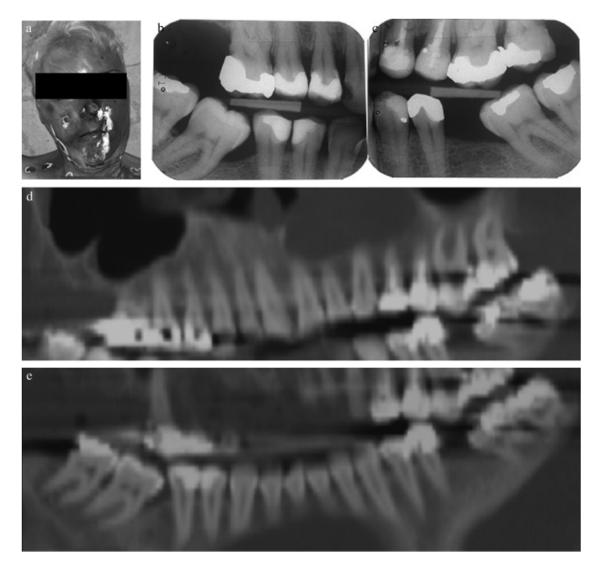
Case IRM 062. (a) A corpse found in an advanced stage of putrefaction. (b) Antemortem right bitewing radiograph. (c) Antemortem left bitewing radiograph. (d) Postmortem upper jaw panoramic reconstruction. (e) Postmortem lower jaw panoramic reconstruction. Note streak artifacts within the panoramic reconstruction due to plenty of metallic restoration that decreases the visibility of some individual restorations. But the additional characteristic teeth position of the lower bitewings allows for a positive identification.
